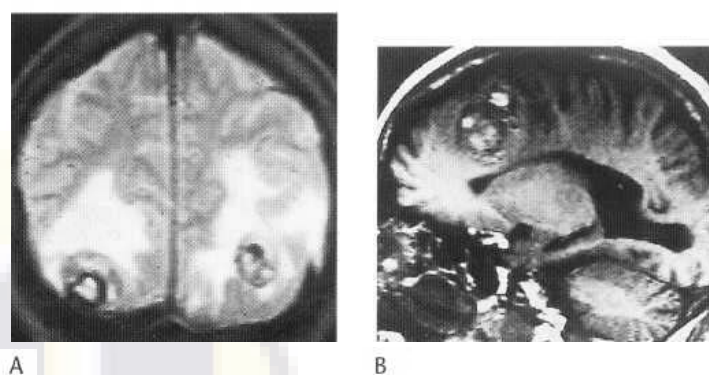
Metastases. (A) Coronal MRI (T₁-weighted). Symmetrical deposits in the occipital lobes. High signal within the deposits probably due to haemorrhage. Surrounding oedema also shown as high signal. (B) Sagittal MRI (T₁-weighted). Frontal lobe adjacent deposits.
